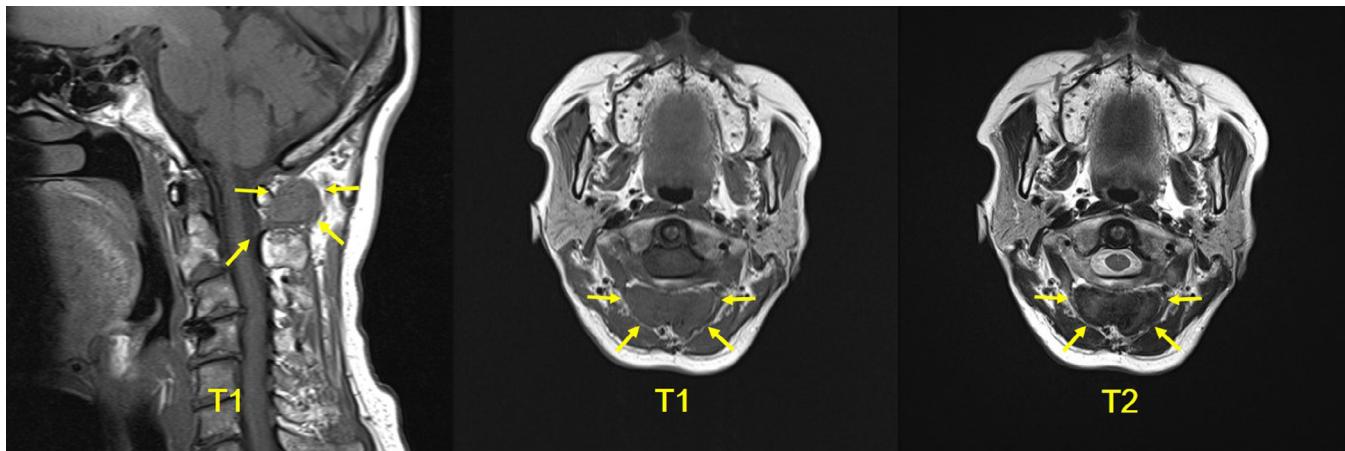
Magnetic resonance imaging (MRI) demonstrated a large, lobulated mass extending from C0 to C2 around the posterior arch of C1 to involve the paraspinal muscles. The mass extended into the spinal canal but did not continue to the facet joints or the occipital condyles. On T1-weighted images, this lesion was isointense to muscles; on T2-weighted images, the mass exhibited heterogeneous signal intensity with slightly increased or decreased signal intensity compared with muscles.
